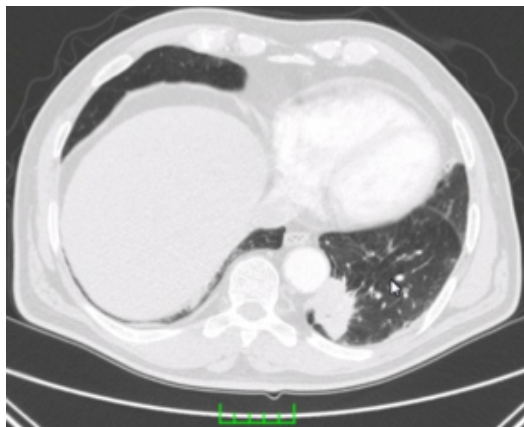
Thorax CT showing mass localized at left lower lobe.
